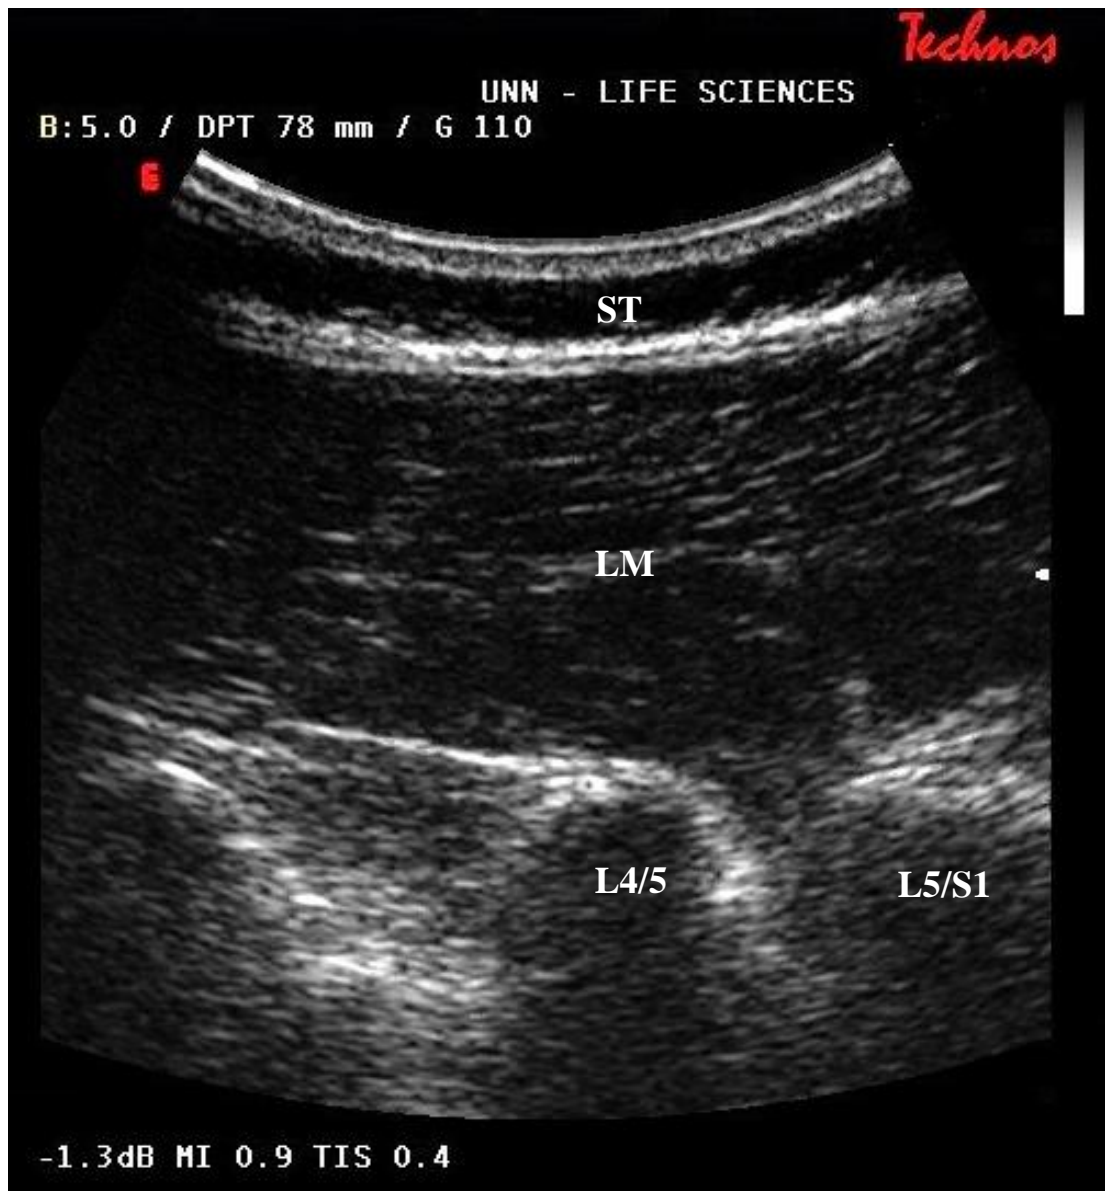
Exemplar captured ultrasound image of the longitudinal view of the lumbar vertebrae including the subcutaneous tissue (ST), *lumbar multifidus* muscle (LM), and the L4/5 and L5/S1 facet joints
